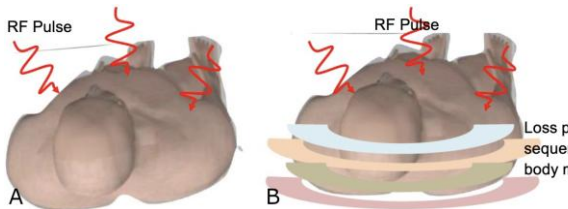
A) RF pulse from the MRI chamber; B) Loss Path in the RF Pulse Sequence
